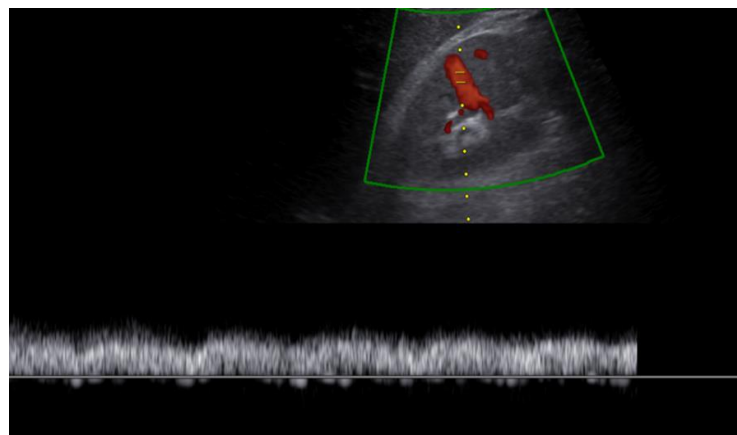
Spectral Doppler displaying low-velocity, continuous venous flow within the cortical vein
